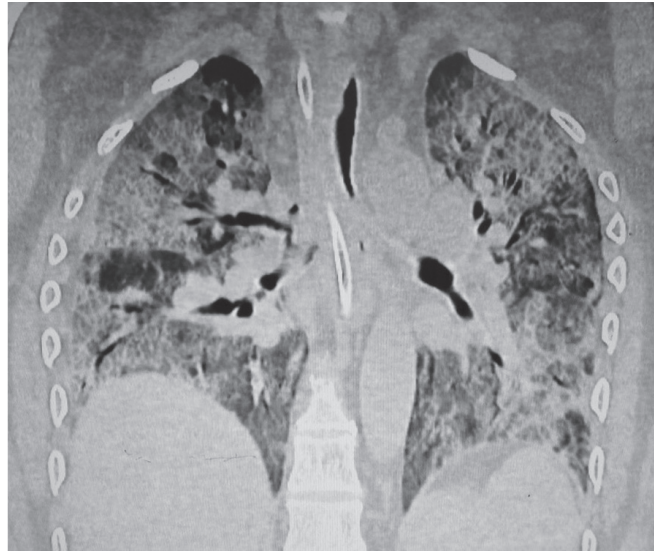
(Patient 1) HRCT chest (noncontrast)
